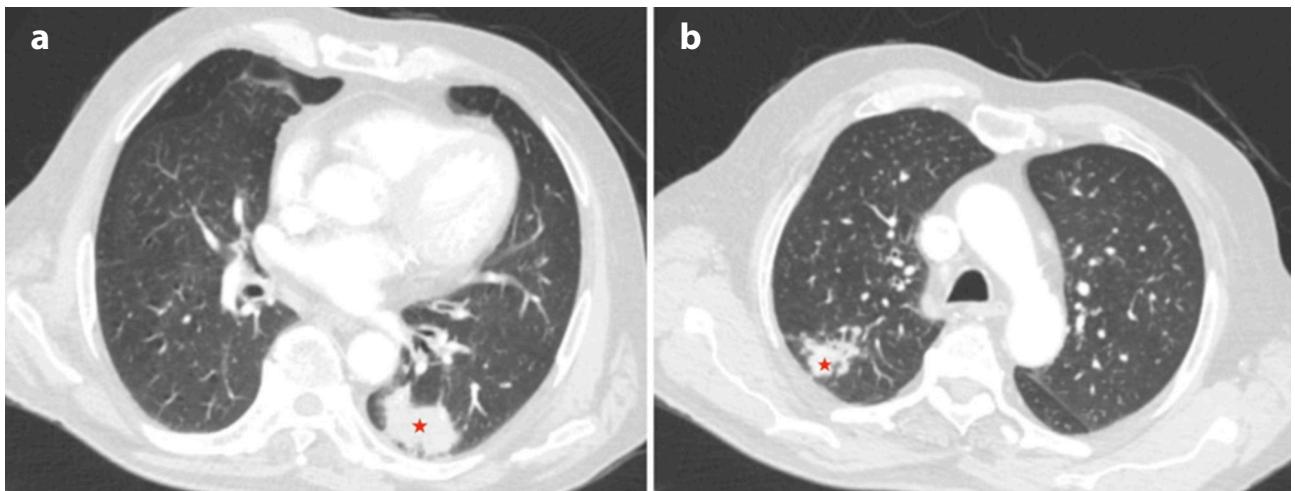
Synchronous tumors located in the right upper lobe and left lower lobe are marked with arrows on thoracic CT images
